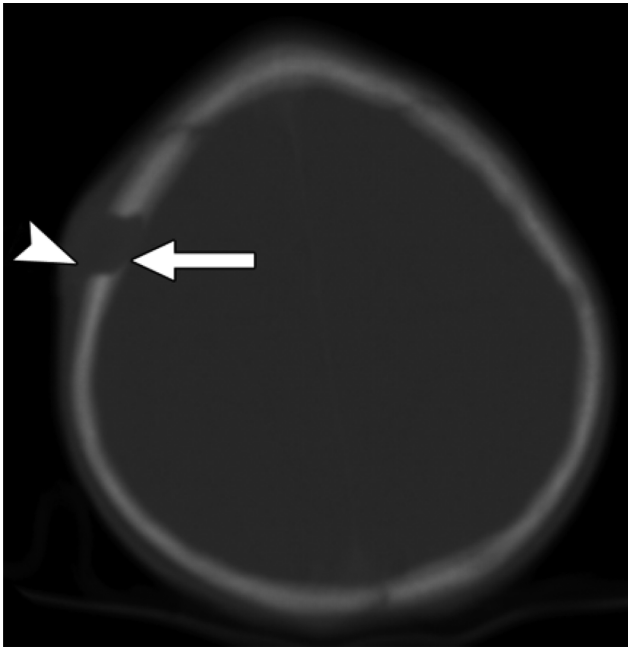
Axial CT shows unequal destruction of outer bone surface (*arrowhead*) and inner bone surface (*arrow*), which produces a beveled-edge appearance.
